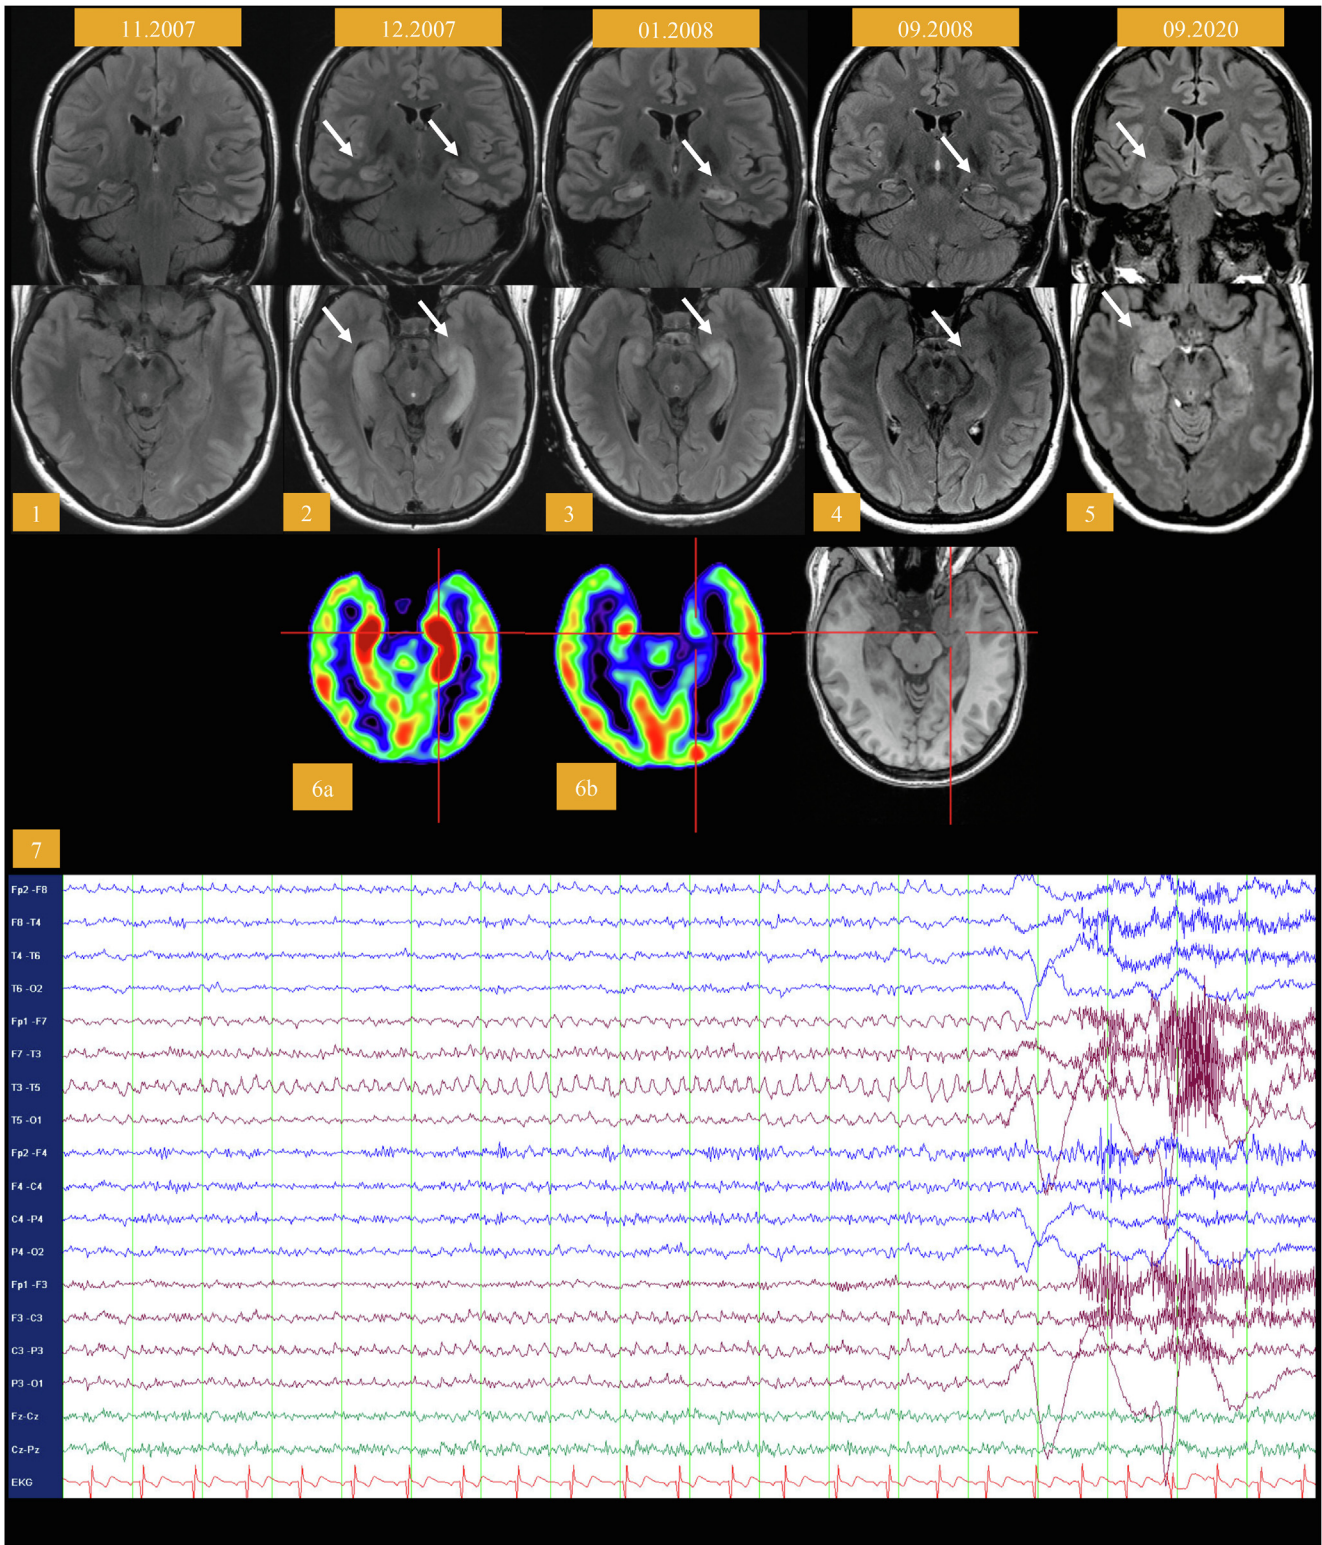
Imaging and electroencephalographic findings of the patient. The figure displays the long-term course of clinical features. MRI described as hyperintensity of the temporomesial structures at disease onset (inflammation) to a mild atrophy of the left hippocampus 1 year after treatment. PET abnormalities change from mesial temporal hypermetabolism at disease onset to mesial temporal hypometabolism 1 month after disease onset. At long-term follow-up swelling and hyperintensity of right amygdala. (1) Normal MRI after 4 tonic-clonic seizures, (2) 1 month after disease onset (global amnesia), (3) 2 months after disease onset (with continued severe amnesia), (4) 10 months after start of immunotherapy (no seizures, functional recovery), (5) 12 years after disease onset (with a swelling of the right amygdala) (6) PET (a) hypermetabolism (b) hypometabolism (7) left temporal seizure onset on scalp EEG (Dec 2007).
